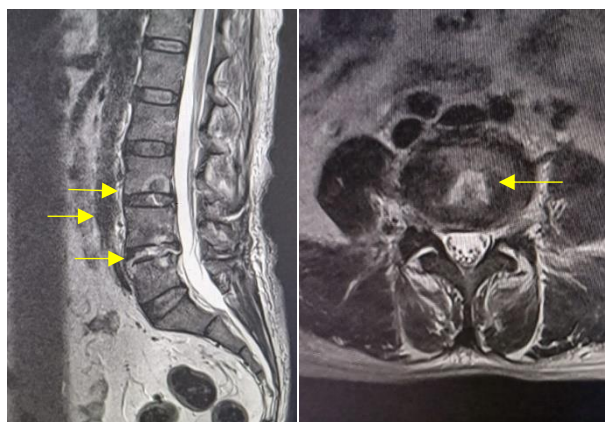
A: Initial MRI (19/09/2023) showing spondylodiscitis of the L4/L5 disc with a small prevertebral collection, degenerative changes at the level of L3/L4
